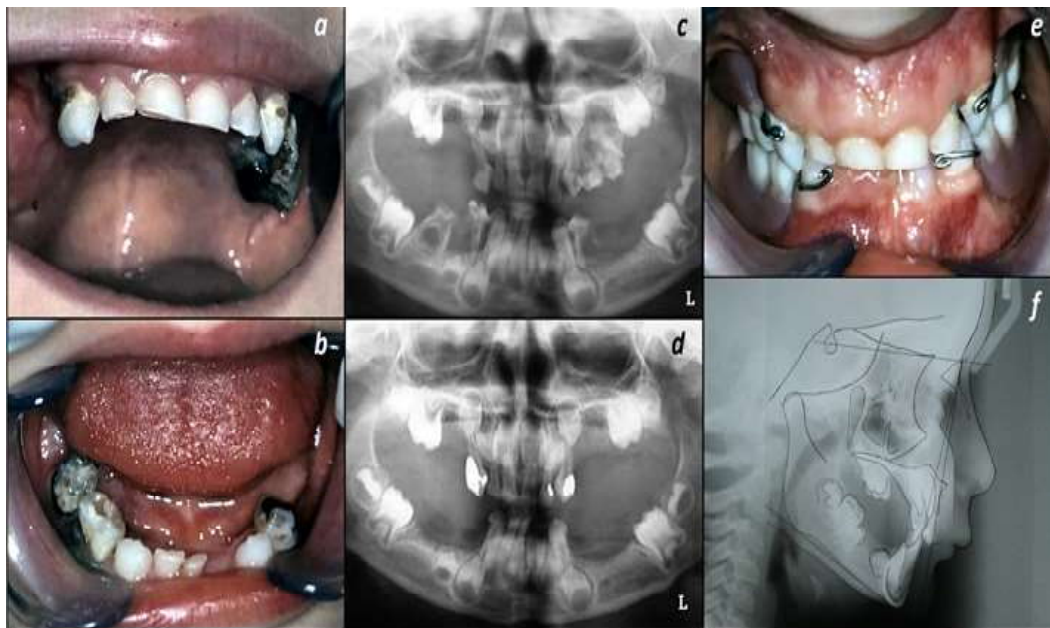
a and b; The clinical appearance of the child's upper and lower jaw. Both of the figures show deciduous molar teeth with extensive profound caries and exposed roots. c; On the orthopantomographic view of the patient deciduous molars appeared like "floating in the air". d; Radiographical appearance of the patient after dental treatments. e; Clinical appearance of the patient with partial removable space maintainers. f; In cephalometric analyses, SNA (82°), SNB ($77,5^\circ$) and ANB ($4,5^\circ$) angles were measured.
